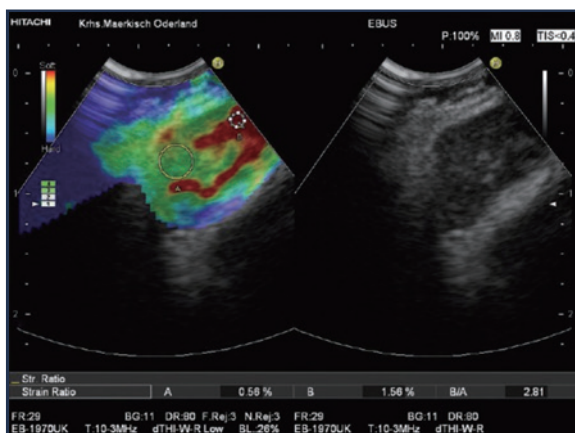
Sarcoid lymph node with homogeneously green appearance and softer hilum in red (Excerpted from Dietrich CF, Jenssen C, Herth FJ. Endobronchial ultrasound elastography. *Endosc Ultrasound*. 2016 Jul-Aug;5(4):233-8.)
